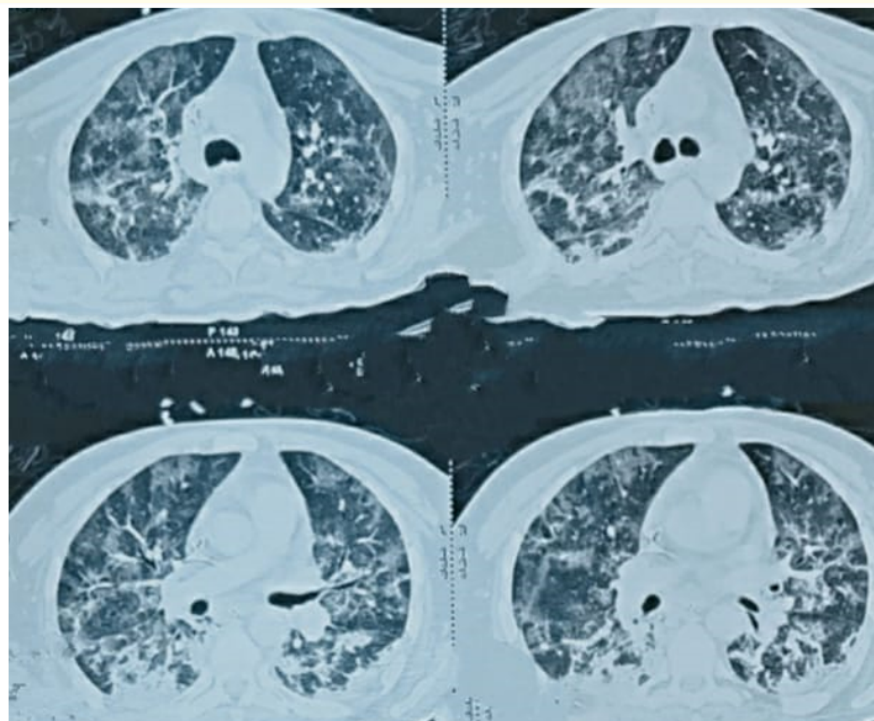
Findings on chest CT scan on admission showing multiple central and peripheral patchy ground glass opacities in bilateral lobular and central with septal thickening that gave the appearance of “crazy paving” and peripheral consolidation diffusely distributed over the two lungs.
